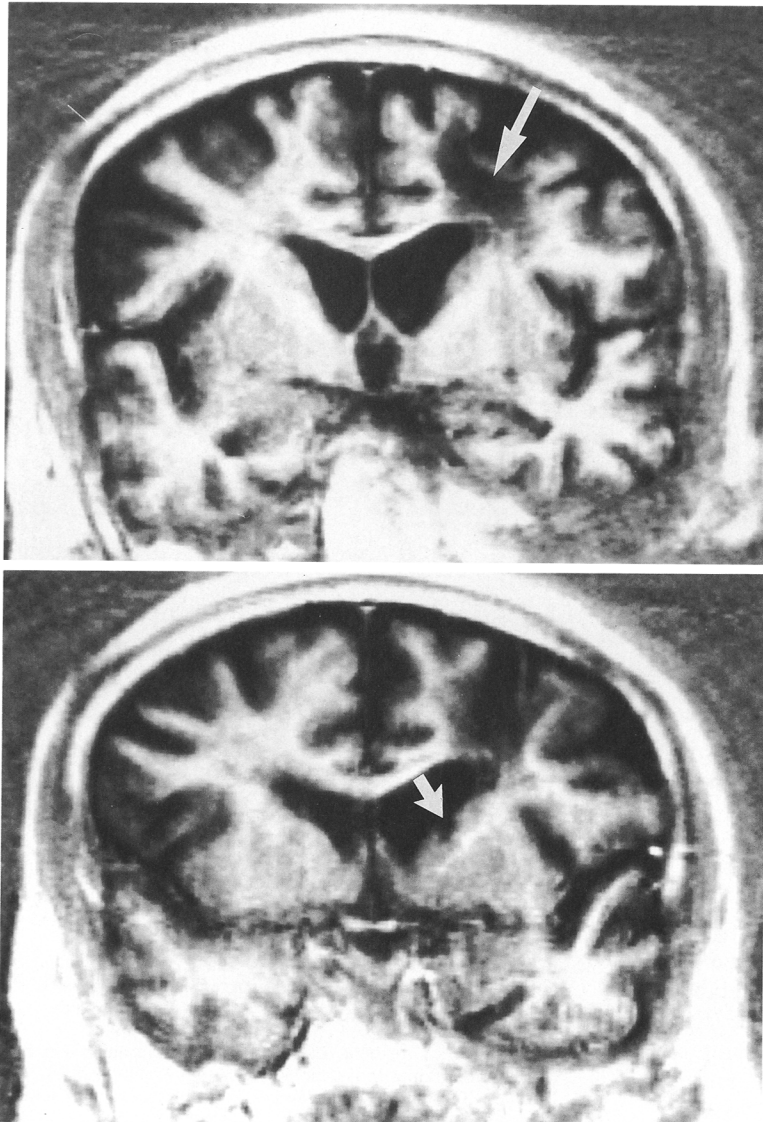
Coronal section of T2-weighted magnetic resonance imaging showing an ischemic lesion in the left centrum semiovale (top) and a lacune in the left caudate nucleus (bottom).
